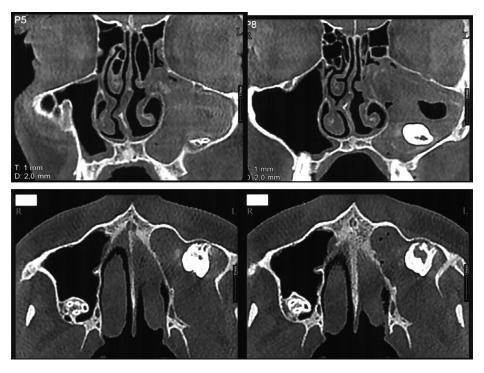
Preoperative coronal and axial computed tomography images. The entire left maxillary sinus is obstructed by a voluminous radiopaque lesion blocking the osteomeatal complex associated to the third upper molar dislocated in the sinus. The coronal scans show the erosion of the posterior wall of the sinus and the invasion of the pterigo-palatine fossa.
